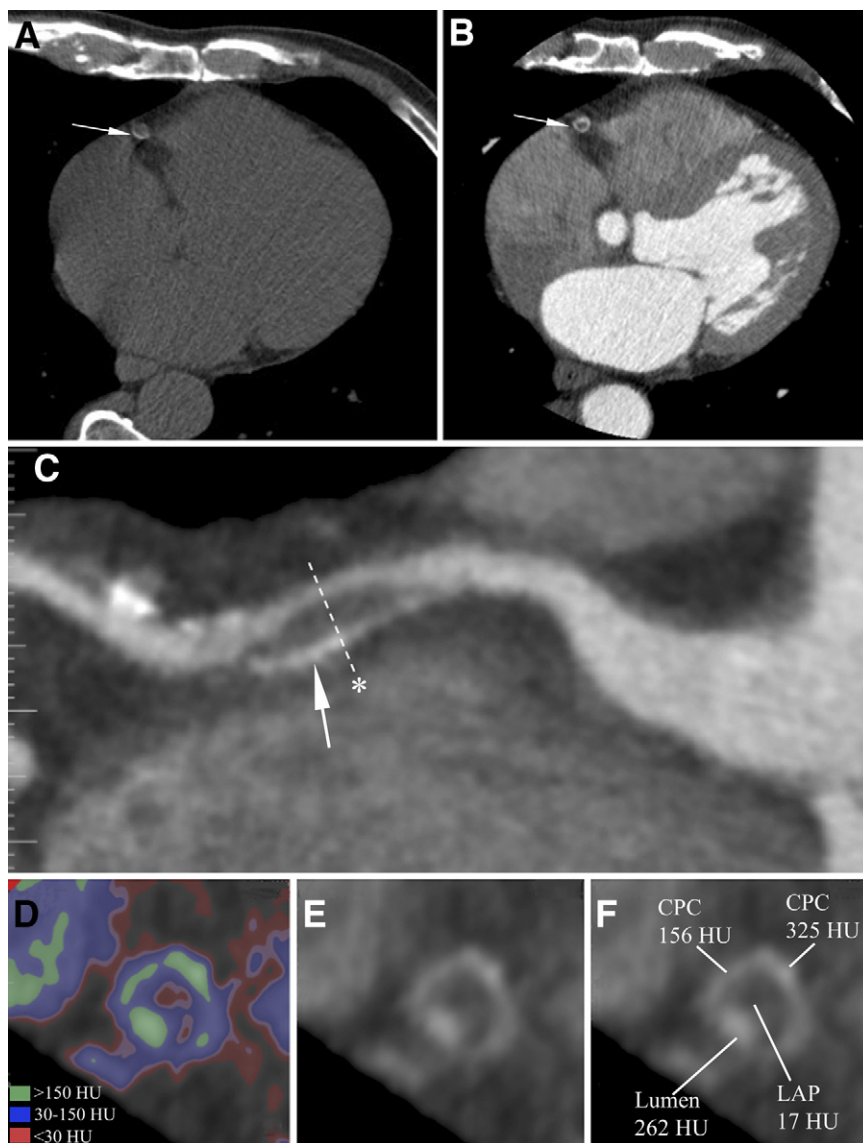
CTA Findings in a Patient Who Subsequently Developed SF During PCI
